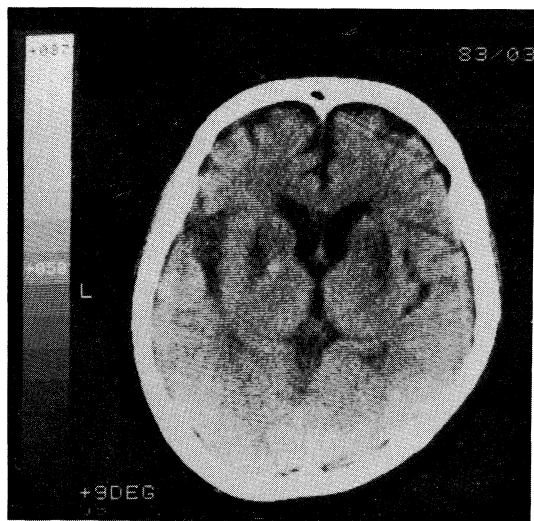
CT scan (3 cm above the orbitomeatal plane, slice thickness 1 cm) showing low-density areas in basal ganglia, a small calcification in the left basal ganglia.
